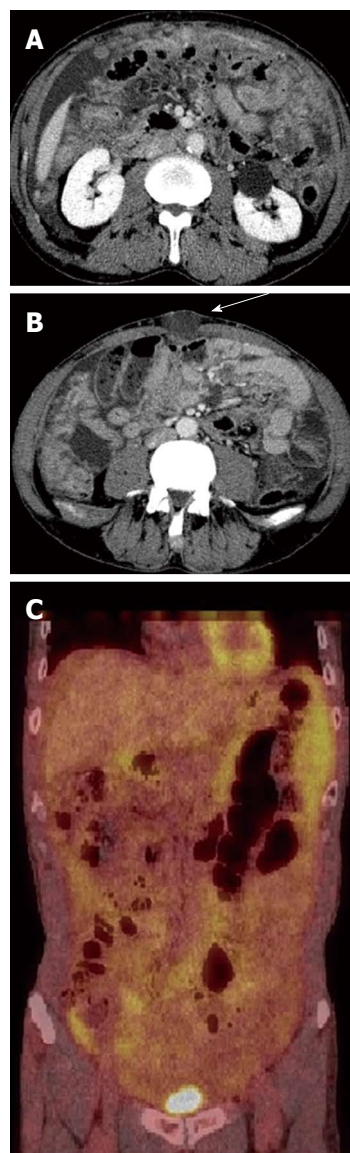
Contrast enhanced computed tomography and ^{18}F -fluorodeoxyglucose-positron emission tomography. A: Thickened peritoneum and mesentery with multiple nodules were positively enhanced by the contrast material; B: An umbilical hernia is also evident (arrow); C: A coronal image of ^{18}F -fluorodeoxyglucose-positron emission tomography (FDG-PET) showed no localized areas of high accumulation of FDG, but mild accumulation of FDG was observed over the entire abdominal region.
